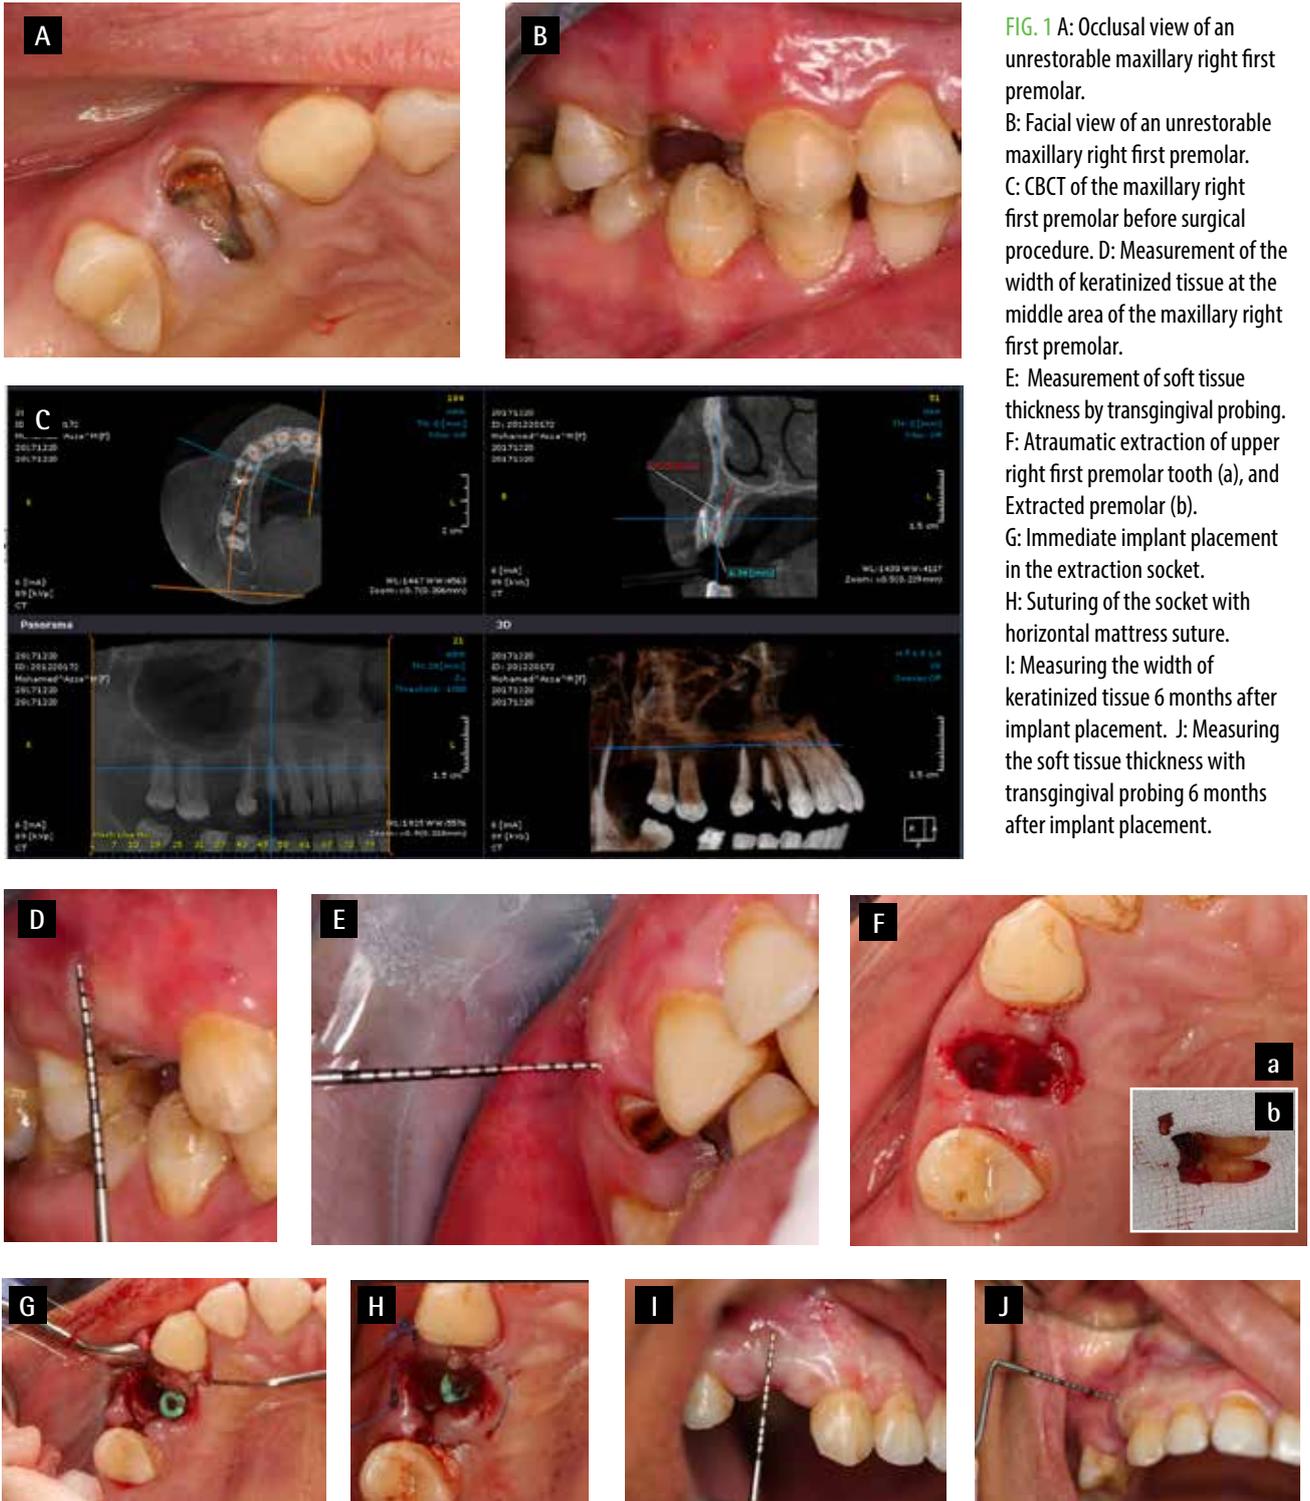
A: Occlusal view of an unrestorable maxillary right first premolar. B: Facial view of an unrestorable maxillary right first premolar. C: CBCT of the maxillary right first premolar before surgical procedure. D: Measurement of the width of keratinized tissue at the middle area of the maxillary right first premolar. E: Measurement of soft tissue thickness by transgingival probing. F: Atraumatic extraction of upper right first premolar tooth (a), and Extracted premolar (b). G: Immediate implant placement in the extraction socket. H: Suturing of the socket with horizontal mattress suture. I: Measuring the width of keratinized tissue 6 months after implant placement. J: Measuring the soft tissue thickness with transgingival probing 6 months after implant placement.
